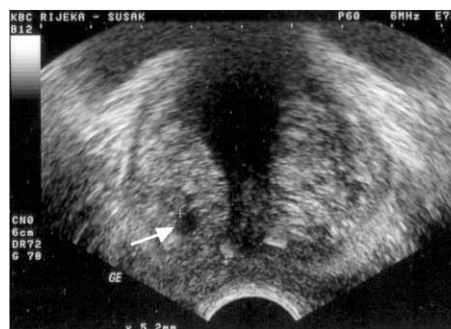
Transrectal sonography showing a hypoechoic prostate cancer lesion (arrow) in the peripheral zone of the right prostatic lobe
